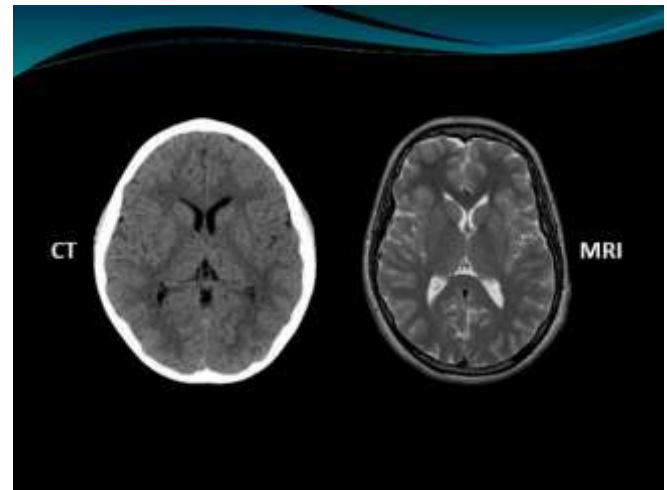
MRI image of Brain
